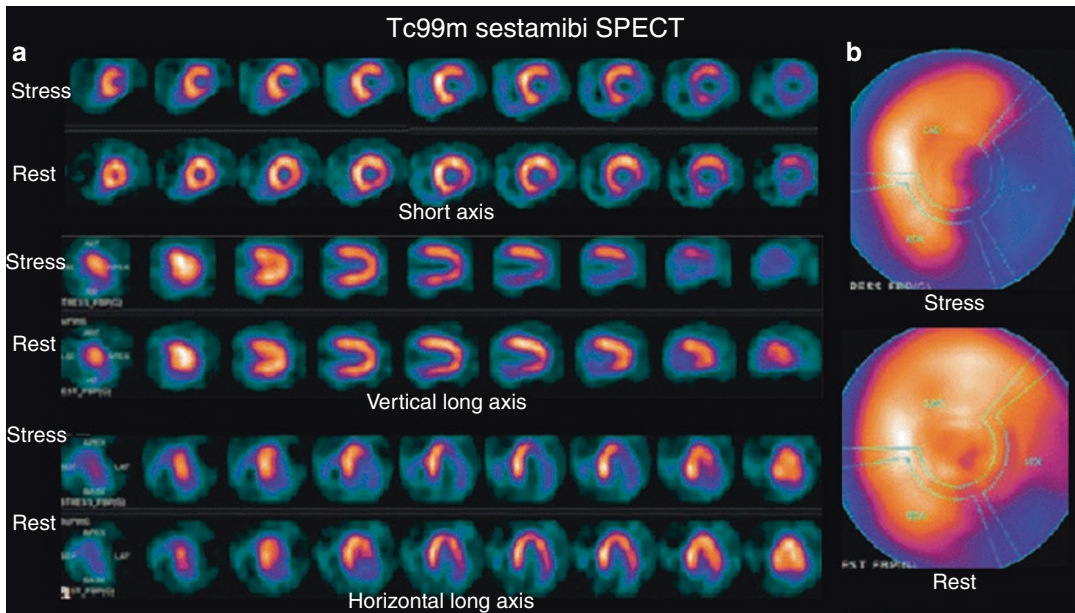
Sixty-year-old male with history of hypertension and CAD and currently complains of shortness of breath. Stress and rest myocardial perfusion SPECT images in short axis, vertical long axis, and horizontal long axis (a) and stress and rest bullseye polar maps (b).
